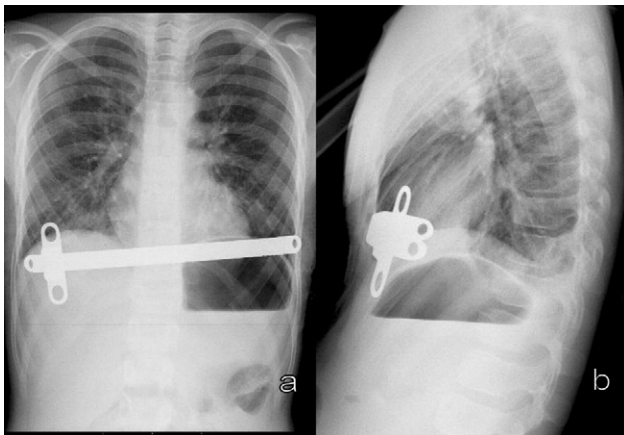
(a) and (b) Postoperative posteroanterior and lateral chest X-rays of the patient.
